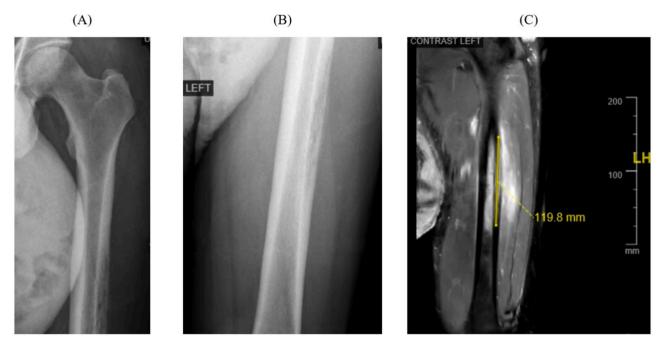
A: Xray (anteroposterior). Permeative appearance of lateral diaphyseal cortex with irregular periosteal reaction concerning for malignancy. B: Same Xray with close up. C: MRI (T2-weighted). Enhancing, eccentric expansile lesion within the mid femoral shaft. Bone marrow and soft tissue edema concerning for osteosarcoma. MRI=Magnetic resonance imaging.
